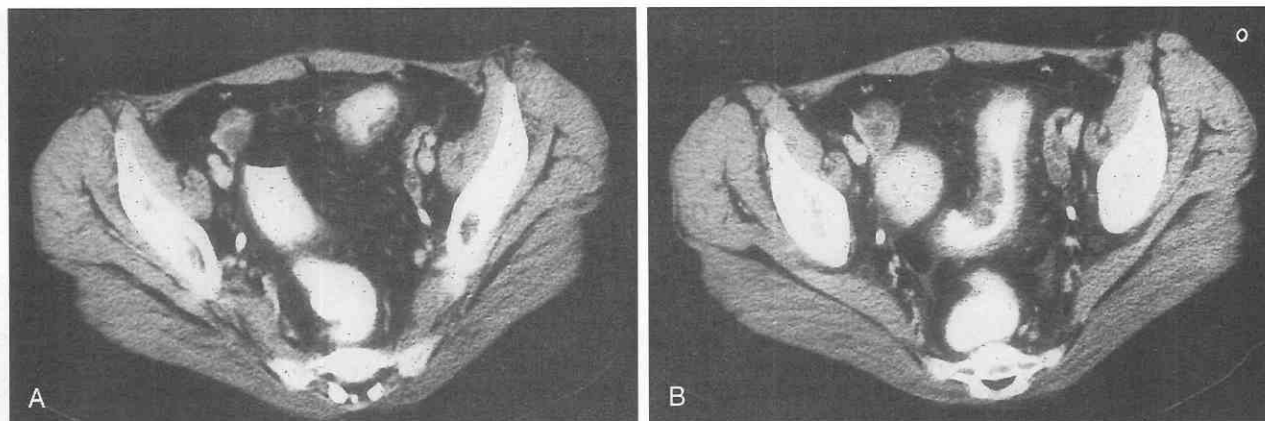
Crohn's disease. A, CT scan through the midpelvis in a patient with Crohn's disease demonstrates marked fibrofatty mesenteric proliferation. B, CT scan in same patient 2 cm below A demonstrates thickening of the sigmoid colon.
